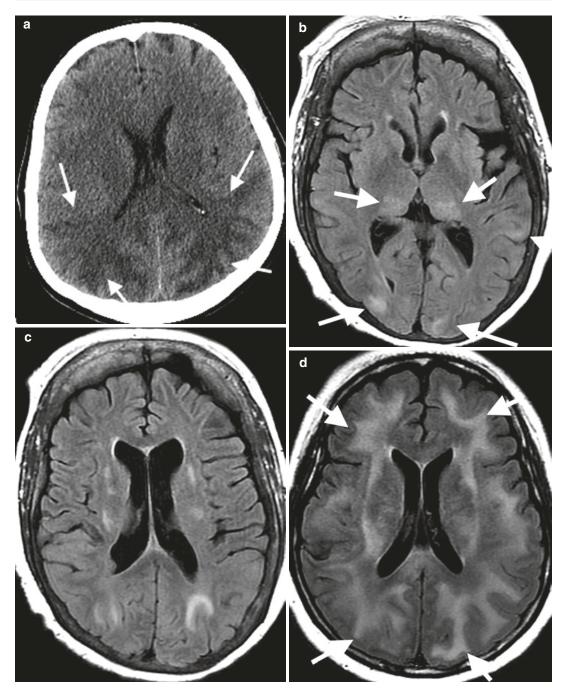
Axial CT of a 25-year-old female with history of SLE with features of PRES on (a) axial CT with extensive posterior circulation deep white matter low attenuation and (\mathbf{b}, \mathbf{c}) a different patient on axial T2 FLAIR MRI with posterior circulation high signal intensity (*arrows*).
